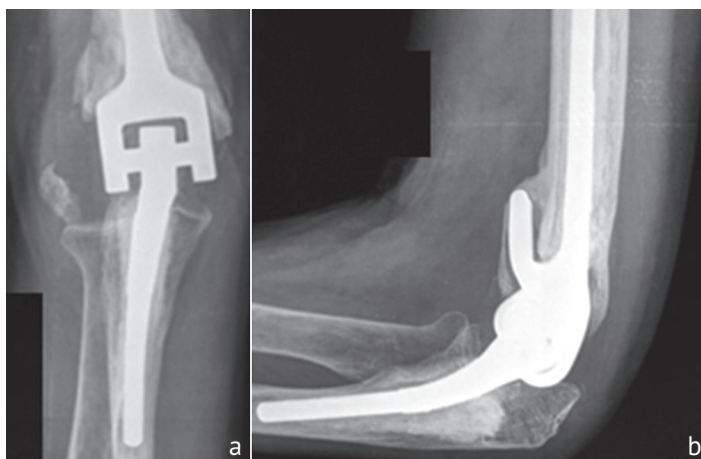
Patient K radiographs of the elbow joint 10 years after TEA: a – AP view, b – lateral view
